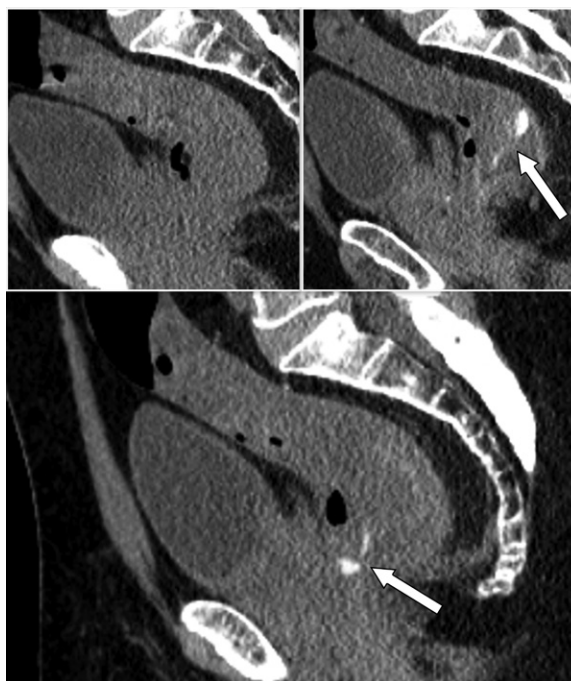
Rectal ulcer causing active GI bleeding in a 59-year-old woman who presented with hematochezia. Sagittal arterial phase (bottom image), noncontrast (top left image), and portal venous phase (top right image) CTA images show foci of contrast extravasation in the lower rectum (arrow in bottom image) which change in size, attenuation, and shape in the portal venous phase (arrow in top right image). A rectal wall ulcer was subsequently found at colonoscopy. (Reprinted, with permission, from reference 13.)
